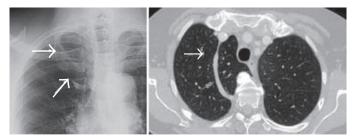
Chest X-ray: Azygos fissure (white arrows) demarcates lateral boundary of azygos lobe. Tear-shaped azygos vein at base of fissure (double arrow).b)azygos lobe in axial CT (Arrow on azygos vein).
